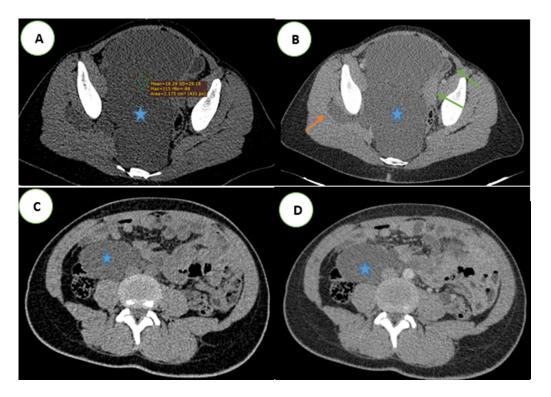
Abdominal-pelvic CT in axial sections without (A, C) and after contrast agent administration at portal time (B, D): shows a large cystic mass (blue star) molding the neighboring structures, pushing back the bladder and the uterus (green arrow) and insinuating itself between the right gluteal muscles (orange arrow).
